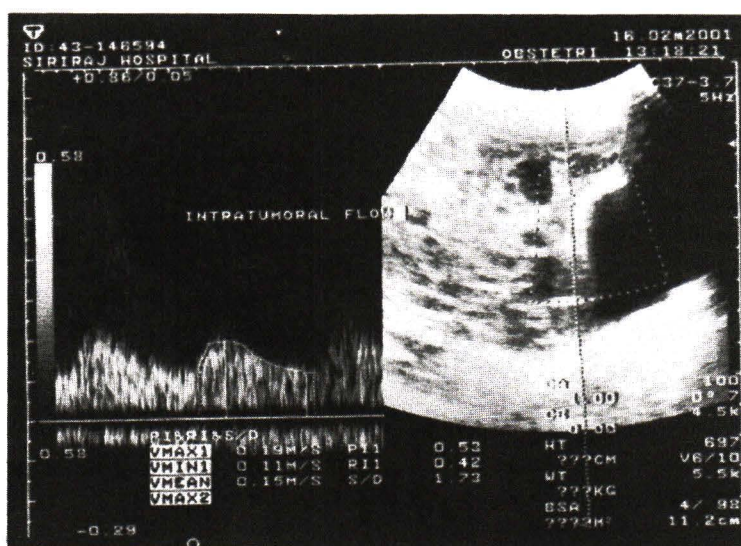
Doppler waveform of the lesion demonstrates low-impedance flow (PI = 0.53). Final diagnosis: granulosa cell tumor.
